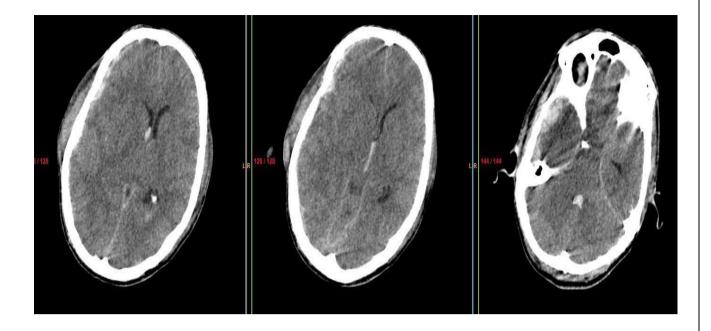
Axial CT scan brain demonstrates intraventricular bleed in bilateral lateral ventricles, 3^{rd} ventricle and 4^{th} ventricle
